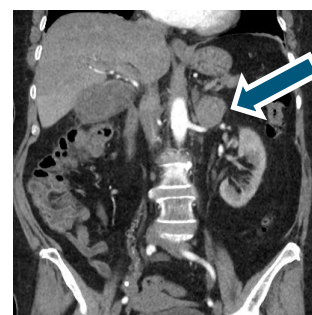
Abdominal CT: Left adrenal nodule
